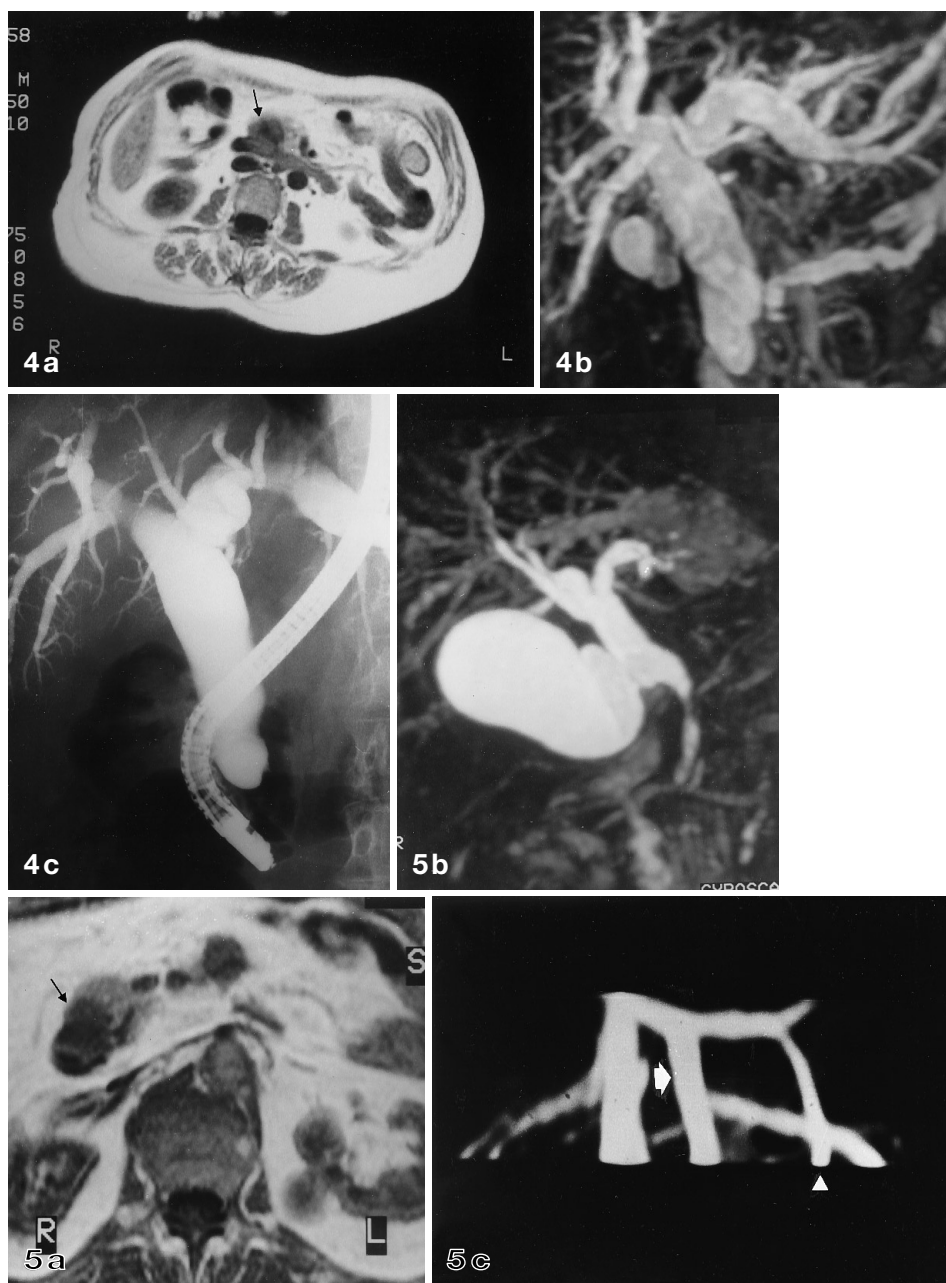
Pancreatic head carcinoma. a T1-weighted SE image shows a reduction in signal intensity of the pancreatic head (*arrow*). b MRCP demonstrates the marked dilatation of the intra- and extrahepatic bile ducts, similarly to ERCP, and the slightly irregular dilatation of the pancreatic duct, with a double duct sign. c At ERCP the Wirsung duct could not be cannulated and therefore not opacified
